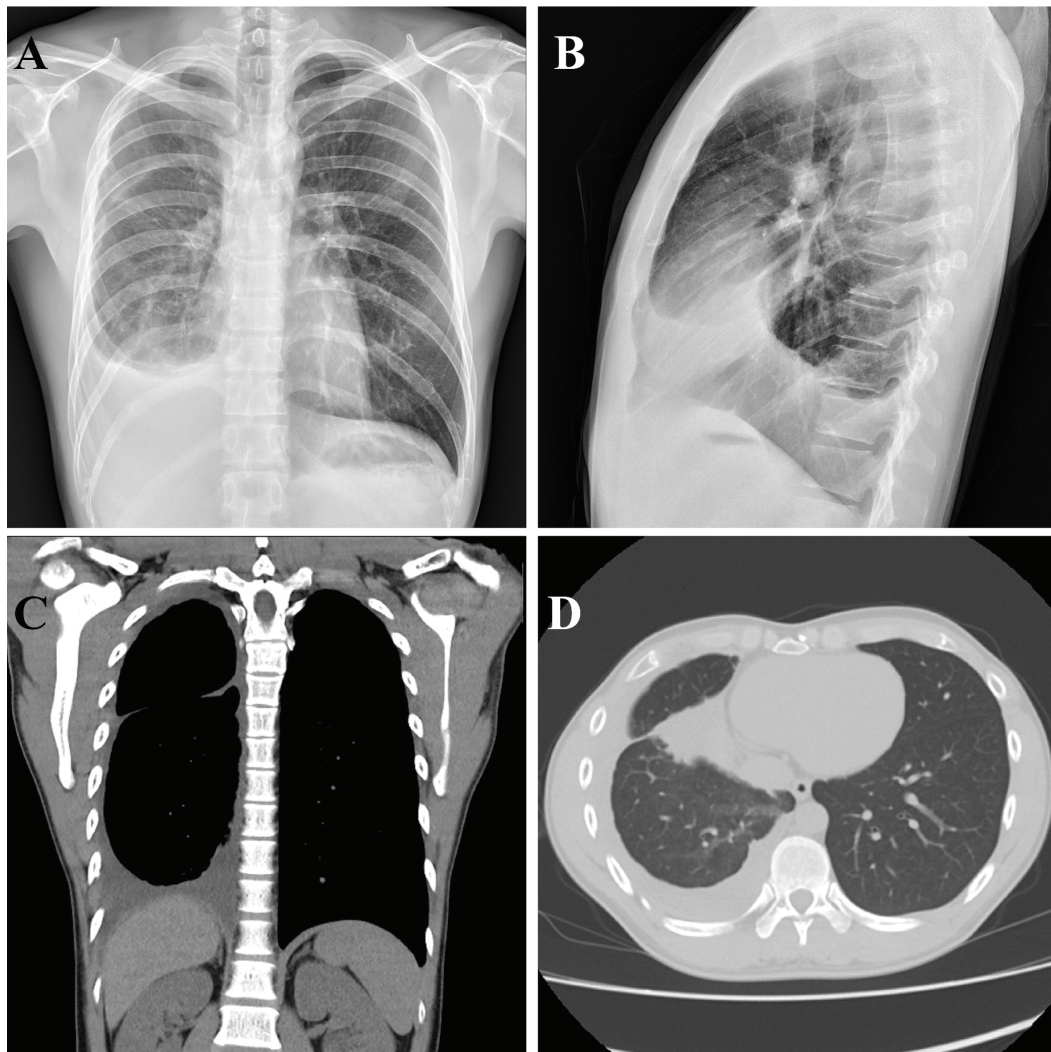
Image findings in the present case. A, B: Chest X-ray showed right-side pleural effusion. C, D: Computed tomography scans showed right-side pleural effusion with right lower lobe consolidation.
